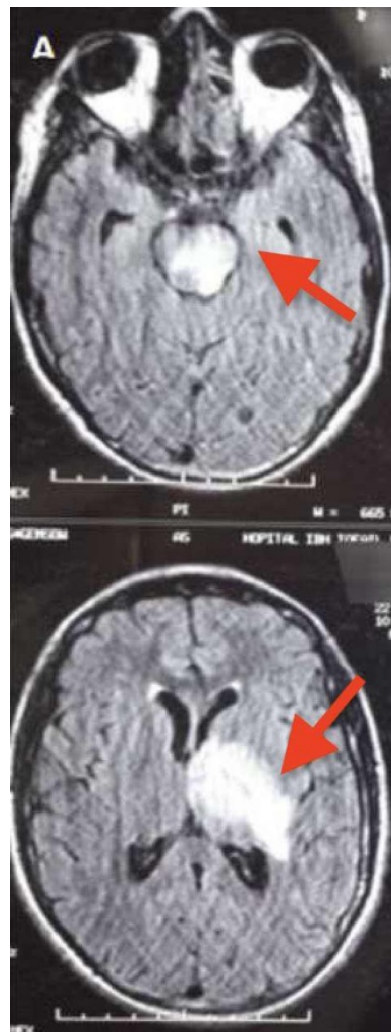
Brain MRI showing axial images demonstrating a bilateral pontine and left capsulo-thalamus lesion, hyperintense on FLAIR-weighted sequence, and little mass effect on the third ventricle.
